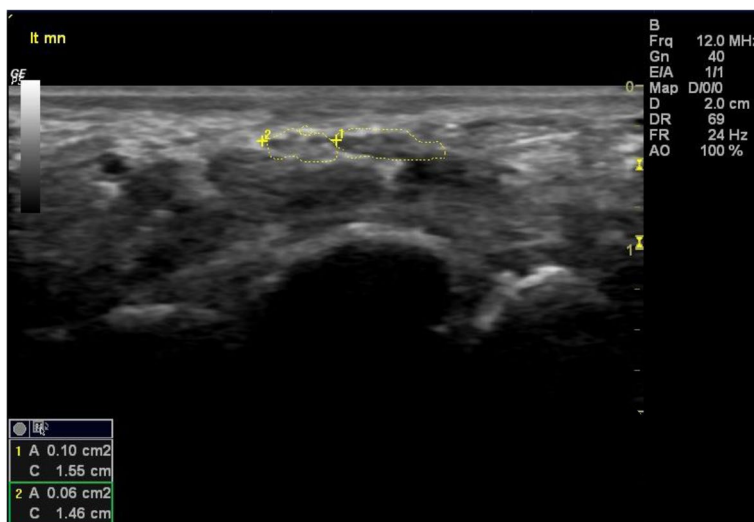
Ultrasound of patient with disease activity score (DAS28) = 5.67 showing left bifid median nerve at the carpal tunnel level with the total cross-sectional area (CSA) (16mm²)
